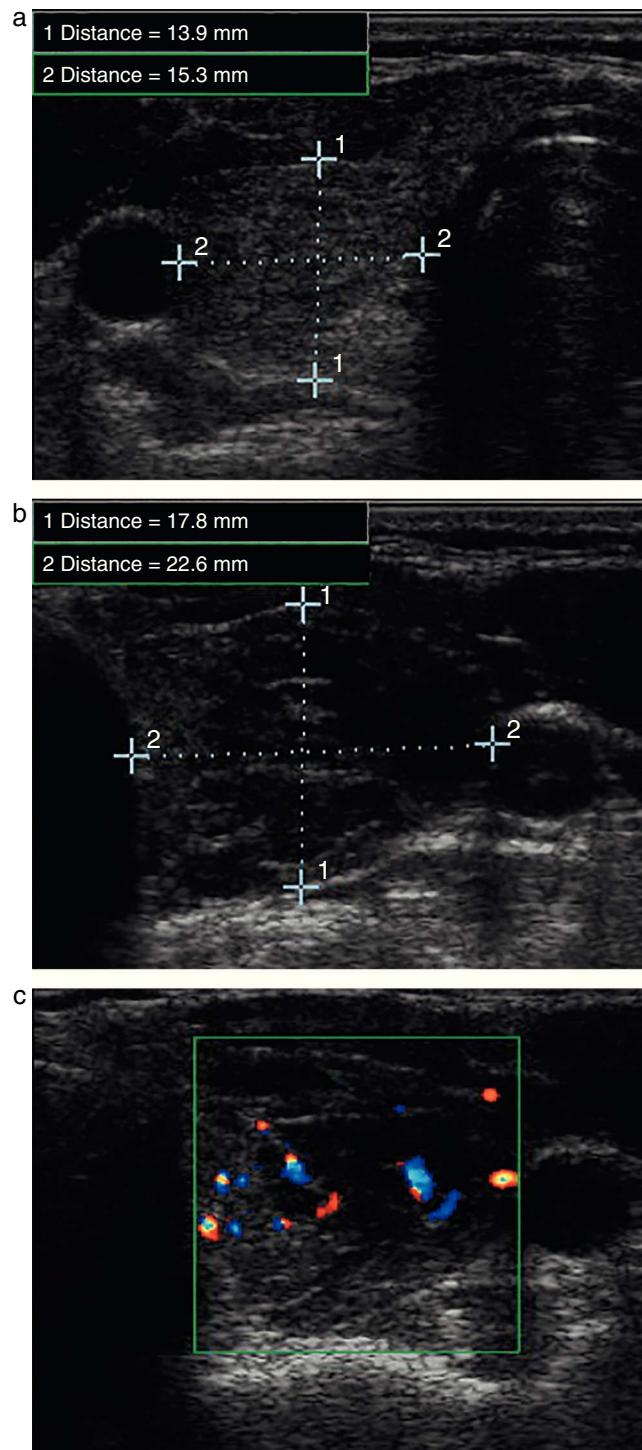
Thyroid ultrasound scan. (a) Right thyroid lobe with typical echogenicity of autoimmune thyroiditis and no nodular formations. (b) Left thyroid lobe occupied by thyroid nodule. (c) Ecodoppler of the left thyroid nodule showing mixed vascularization.
